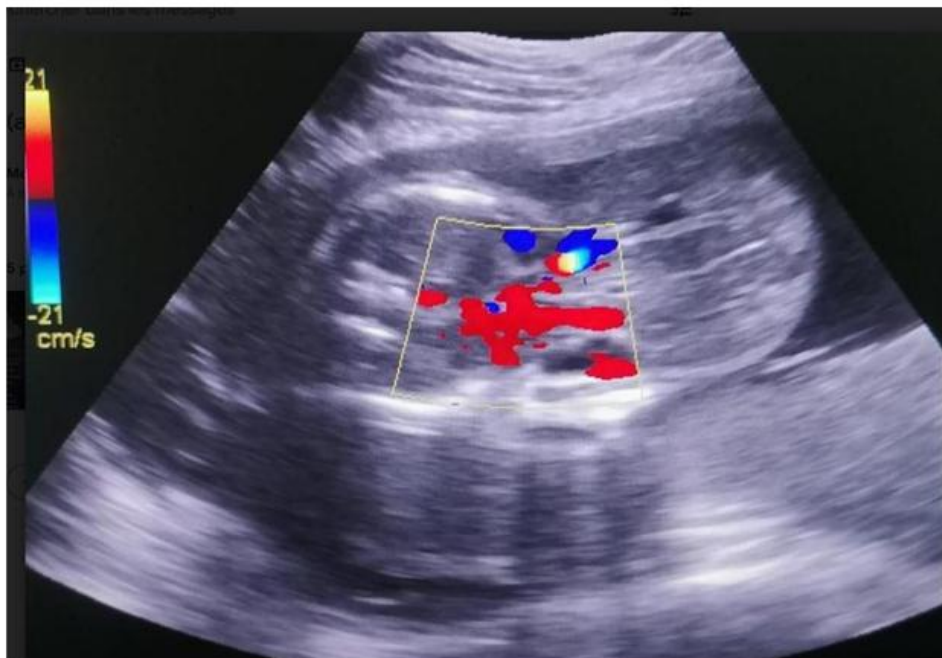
demonstration of a Doppler vascularization confirming the position of the cord.
